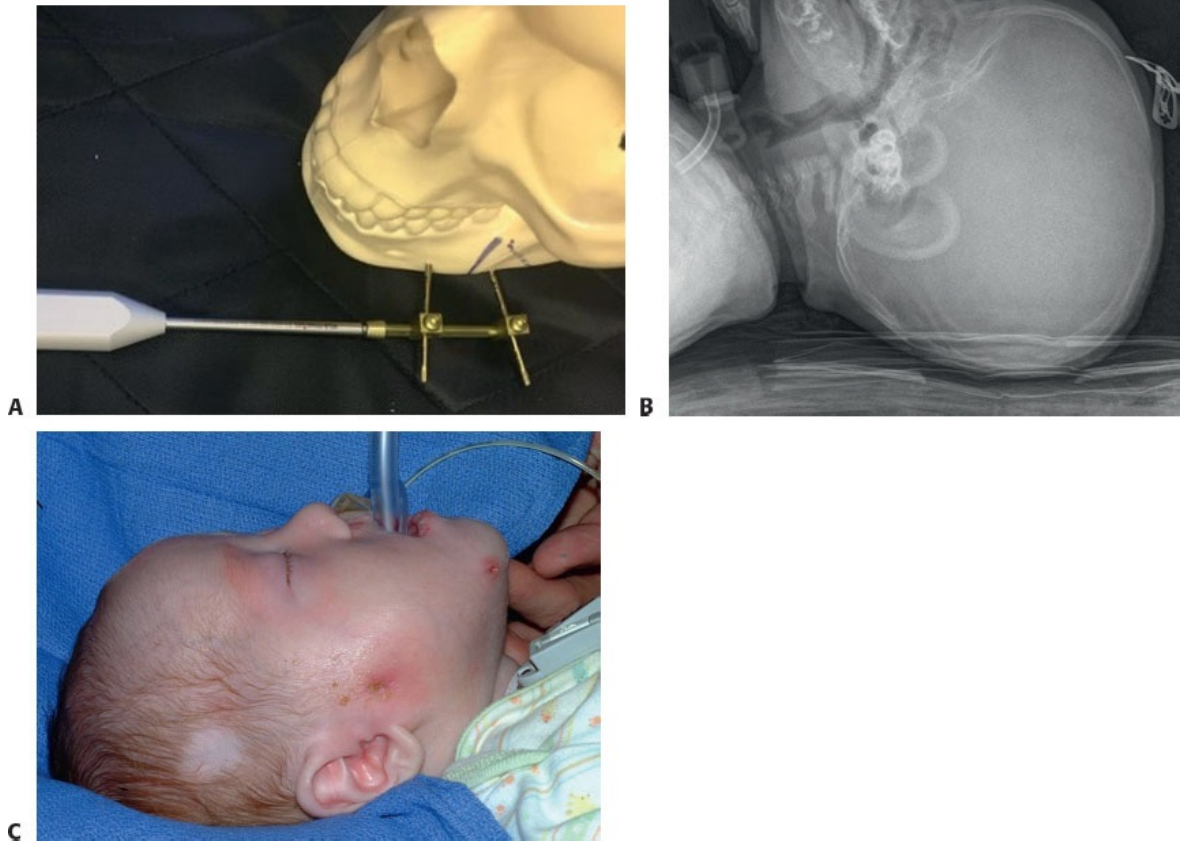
• A. Driver engaging the distractor arms and turning. B. Bedside radiograph demonstrating advancement of the mandible and improvement of the airway. C. A neonate at the time of distractor removal demonstrating overcorrection of the mandible.
